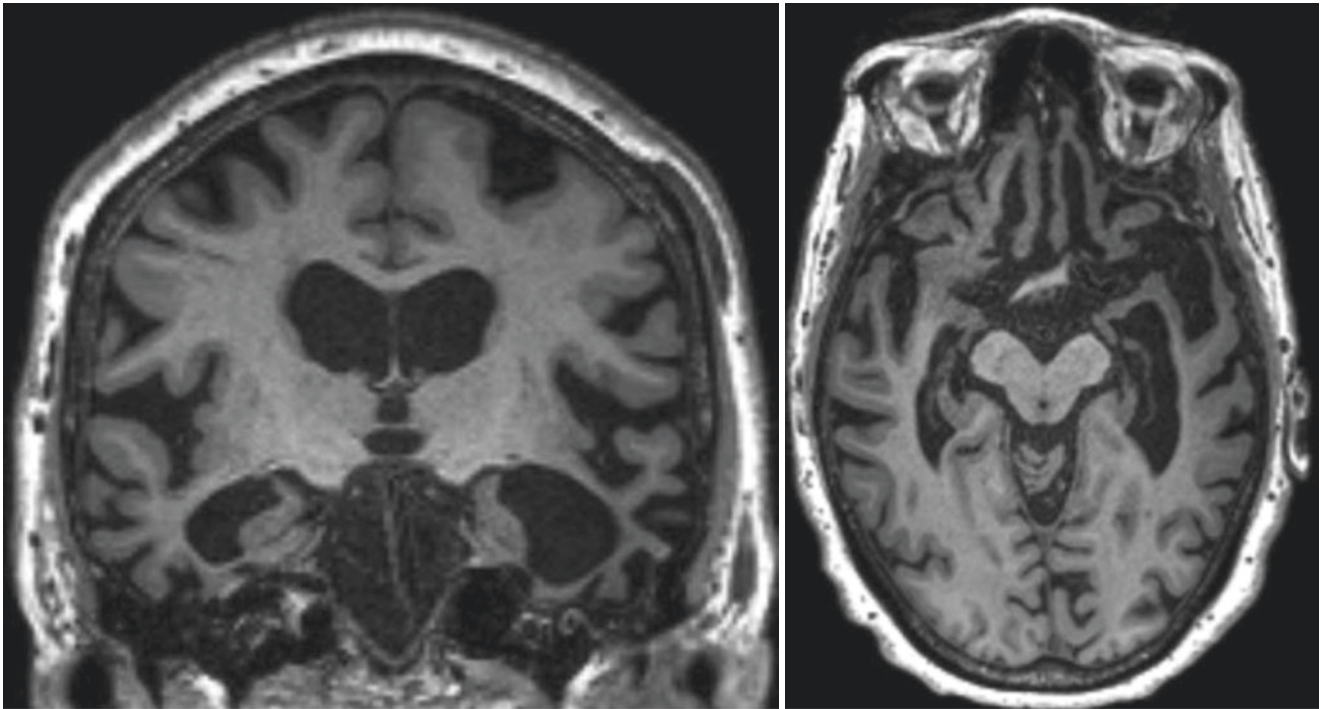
Magnetic resonance imaging (MRI) of an 82-year-old patient with behavioral variant FTD. Predominant focal atrophy in the anterior and inferior temporal, orbitofrontal, and insular regions, right
